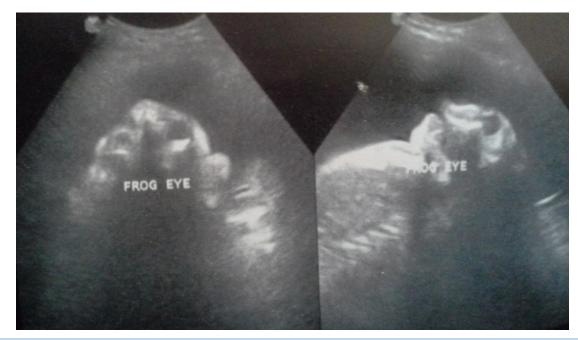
These are obstetric ultrasonograms demonstrating the so called "frog eye" appearance of anencephaly and absent skull vault in both images. Associated marked amount of amniotic fluid volume (polyhydramnious) is also demonstrated.
